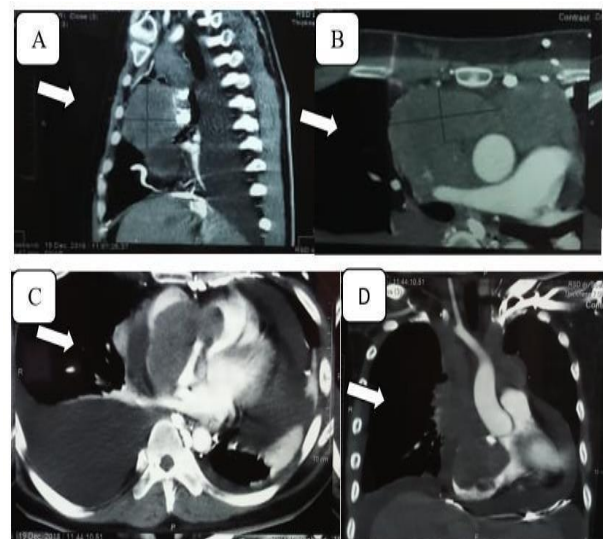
Contrast thoracic CT. A. Sagittal plane. B. Axial plane. C. Pericardial effusion (arrow) D. Suspected thrombus tumor, differential diagnosis of atrial myxoma (arrow)
